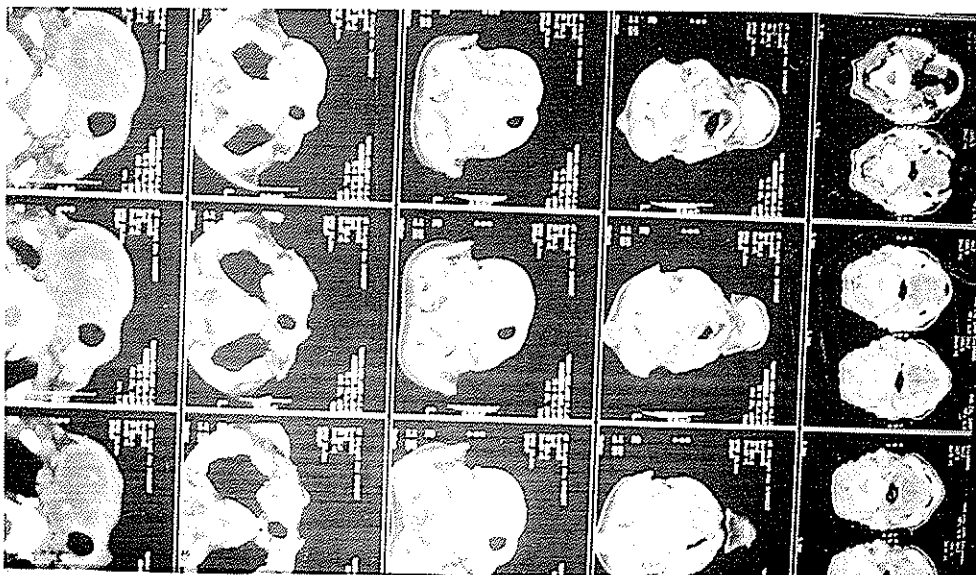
Neck CT - scan demonstrating a hypodense right thyroid lobe mass with internal calcification.
